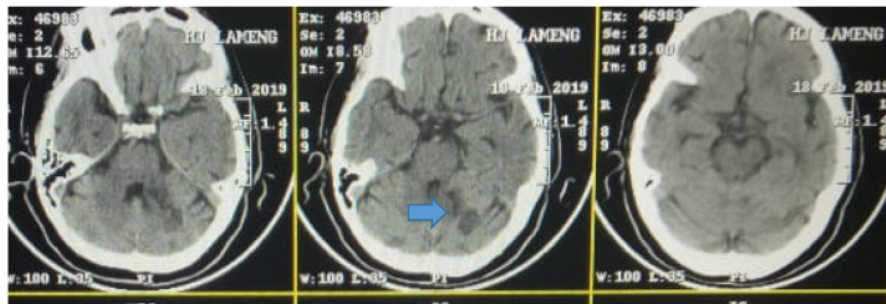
The result of head CT scan without contrast. There were multiple hypodense lesion on the left cerebellum (19HU). In addition, there were also hypodense lesion on the left mesencephalon. The hypodense lesion indicates an ischemic stroke in that area.
